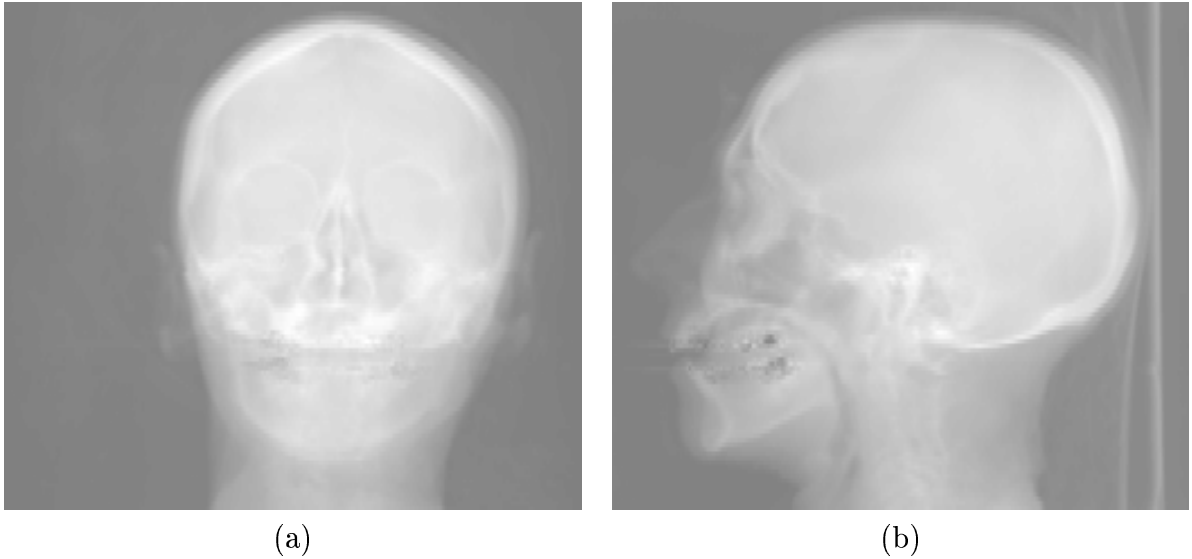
Two orthogonal projections (a)–(b) of the 3-D CT scan of a head.
